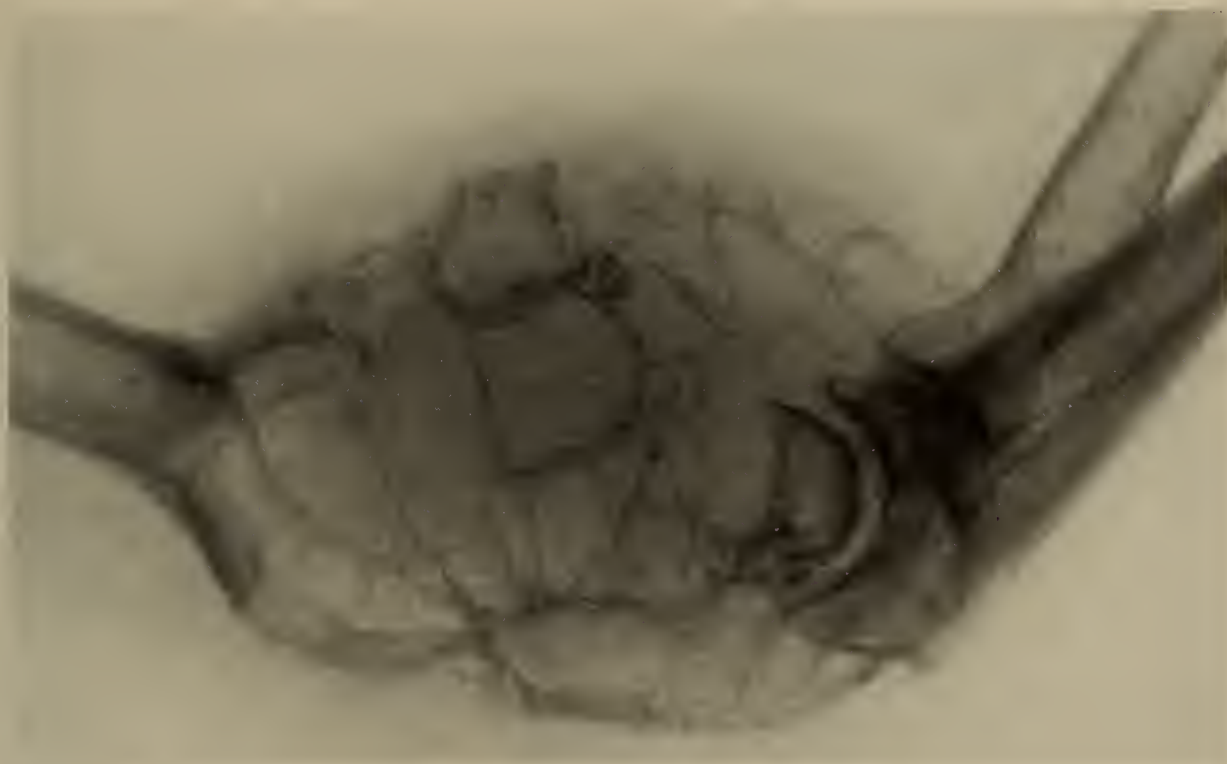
Courtesy of Memorial Hospital, New York City. Typical roentgenogram of a giant cell tumor.
